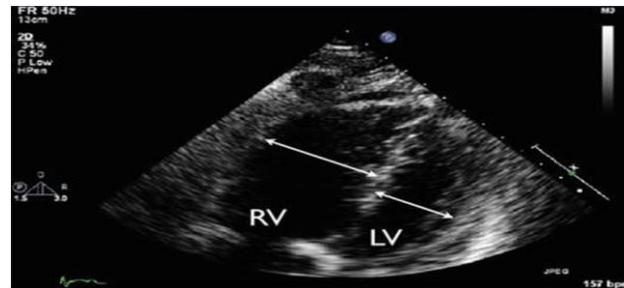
Transthoracic echocardiography showing enlarged right heart cavities
